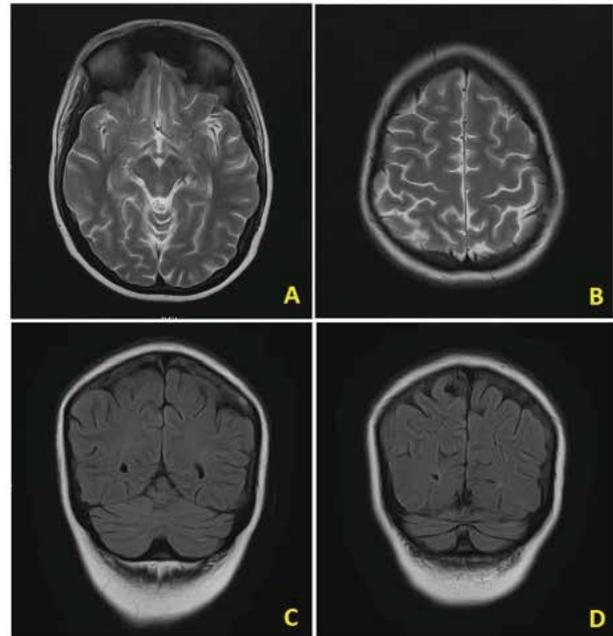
Follow-up MRI Brain showing resolution of diffuse hyperintense signals in bilateral cerebral hemispheres in T2/FLAIR sequences shown in figure 1.
